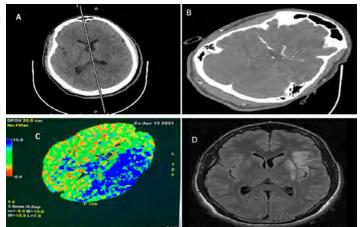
Patient brain imaging demonstrating a left sided infarct. A. CT slices of brain for imaging. No abnormality was shown on image analysis. B. CT angiogram demonstrating a thrombus in M1. C. MTT perfusion imaging showing reduced blood flow. D. MRI of the brain without contrast demonstrating an infarct in the left MCA distribution.
